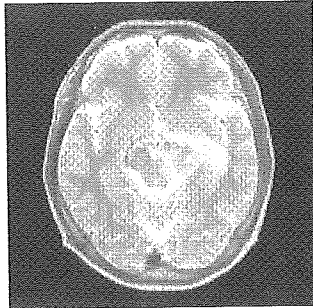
神経Behçet病(MRI T<sub>2</sub>強調画像)
